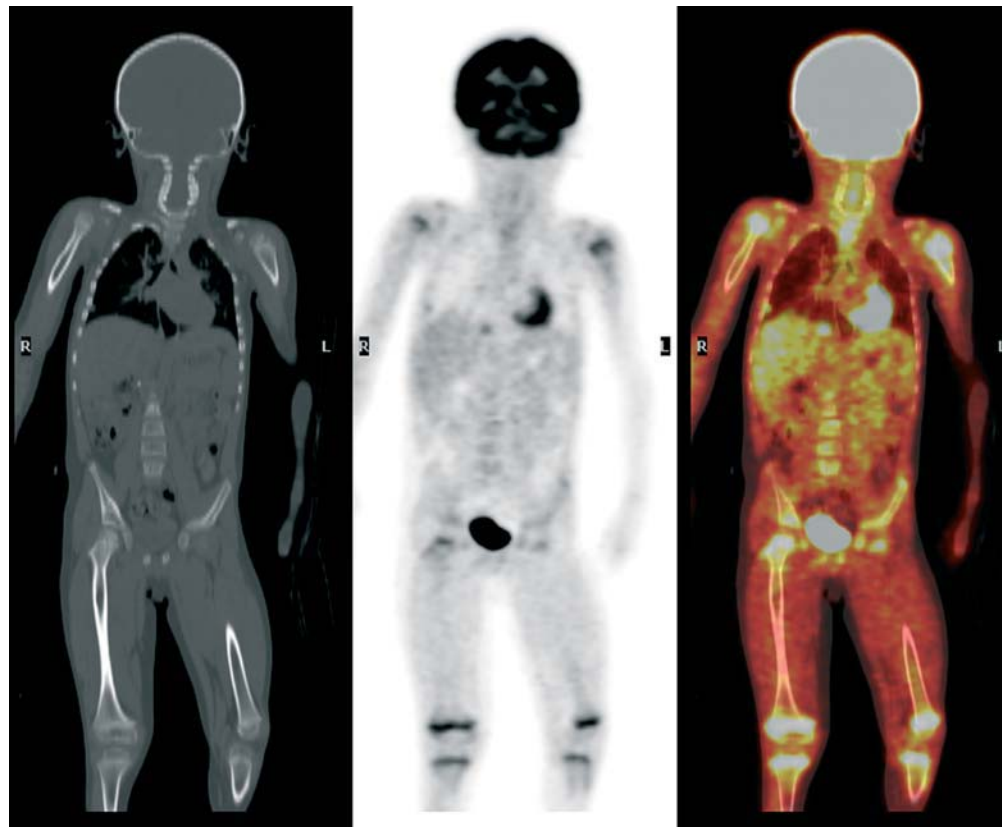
Five-year-old boy with history of T-cell large cell anaplastic lymphoma. Coronal images from PET/CT obtained before bone marrow transplantation. *Left panel:* CT of neck, chest, abdomen, pelvis, and thighs. *Center panel:* FDG-PET of same area shows normal-appearing thymic activity, left greater than right, in the superior mediastinum. *Right panel:* Fused PET/CT image overlays the metabolic information from the FDG-PET study onto the anatomic map provided by the CT images.
